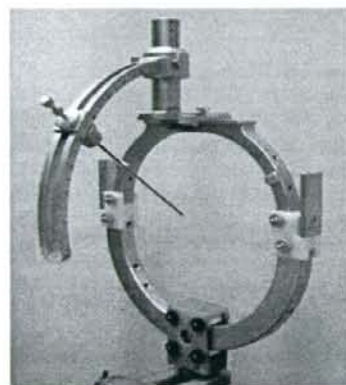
Radio-frequency receiver coil integrated with a modified Koral stereotactic frame for stereotactically guided surgical procedures under the control of intraoperative MRI.
